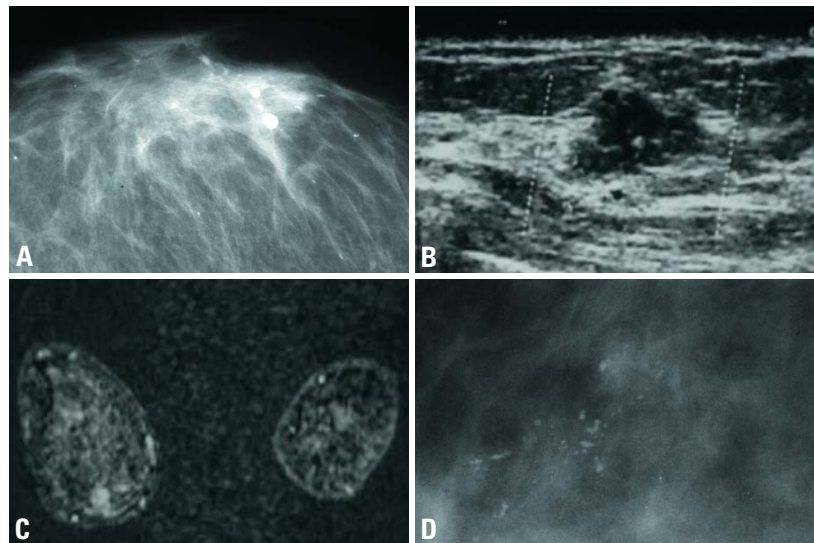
Ductal carcinoma in situ images. A This galactogram was performed because of pathologic discharge from a single duct. On the galactogram multiple filling defects and truncation of the duct (approx. 4 cm behind the nipple) are demonstrated. B Low grade cribriform DCIS. In this patient, an ill circumscribed nodular nonpalpable (8 mm) low grade cribriform DCIS was detected by ultrasound. C MRI of an intermediate grade papillary DCIS. A strongly enhancing somewhat ill circumscribed lesion is visualized at 6 o'clock in the patient's right breast (coronal plane). D High grade comedo-type DCIS. Highly suspicious coarse granular and pleomorphic microcalcifications are shown, which follow the ductal course indicating presence of a DCIS.
